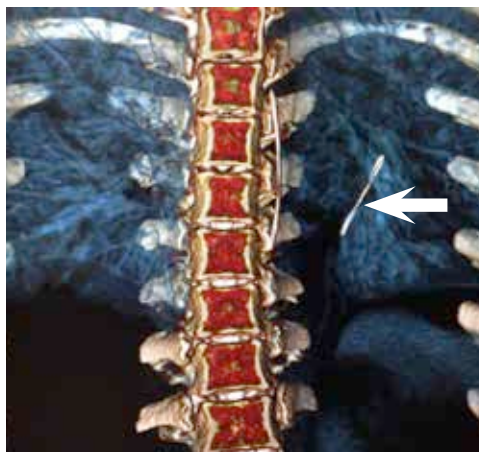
Computed tomography image reconstruction of thorax. Note the head of the pin pointed inferomedially at the left tertiary bronchus.
